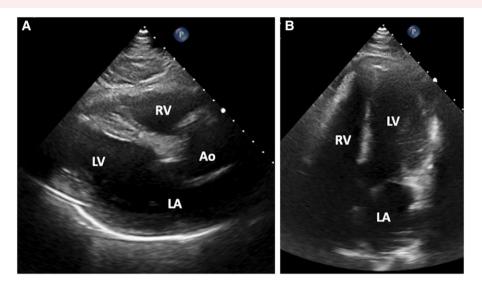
Post-operative parasternal long (A) and apical four-chamber (B) transthoracic echocardiogram images displaying resolution of large left ventricular aneurysm and pericardial effusion.
